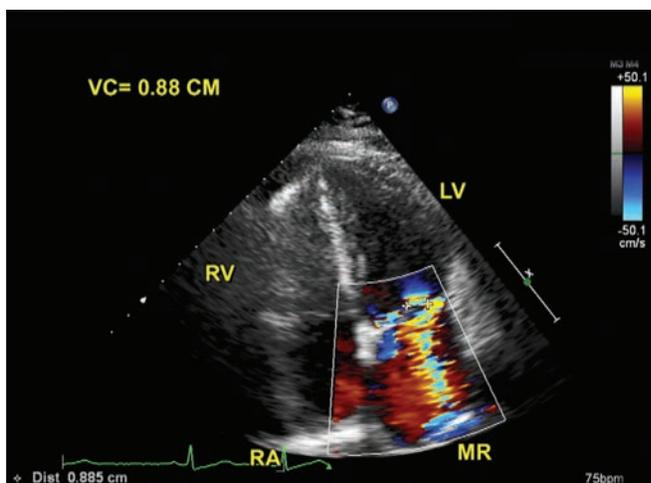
Apical four chamber view. MR vena contracta (VC) measured 0.88 cm.
